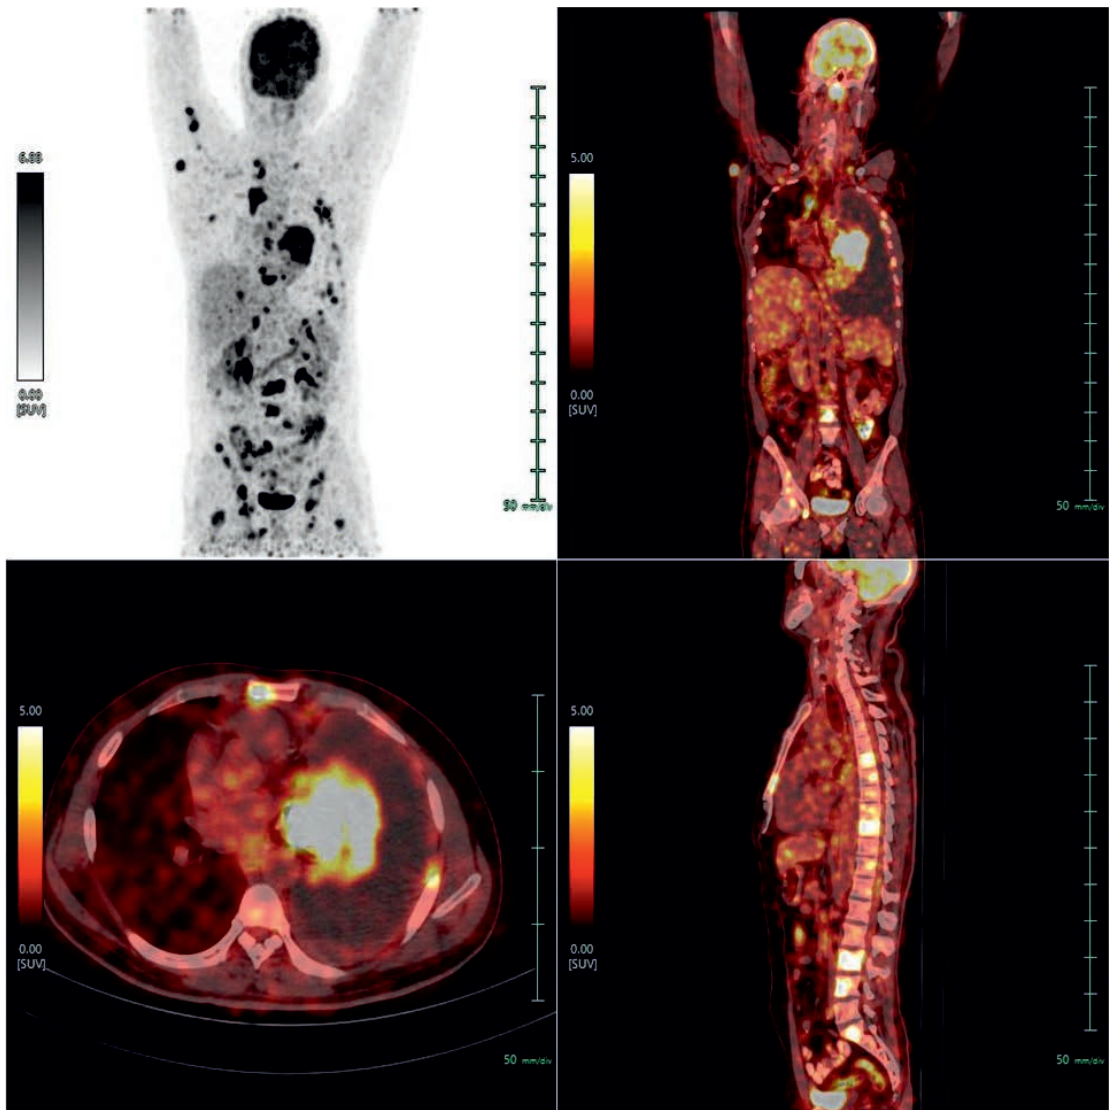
^{18}F -FDG PET/ CT FOR CARCINOMA STAGING. ^{18}F -FDG-PET/ CT was done in a patient with carcinoma lung shows
